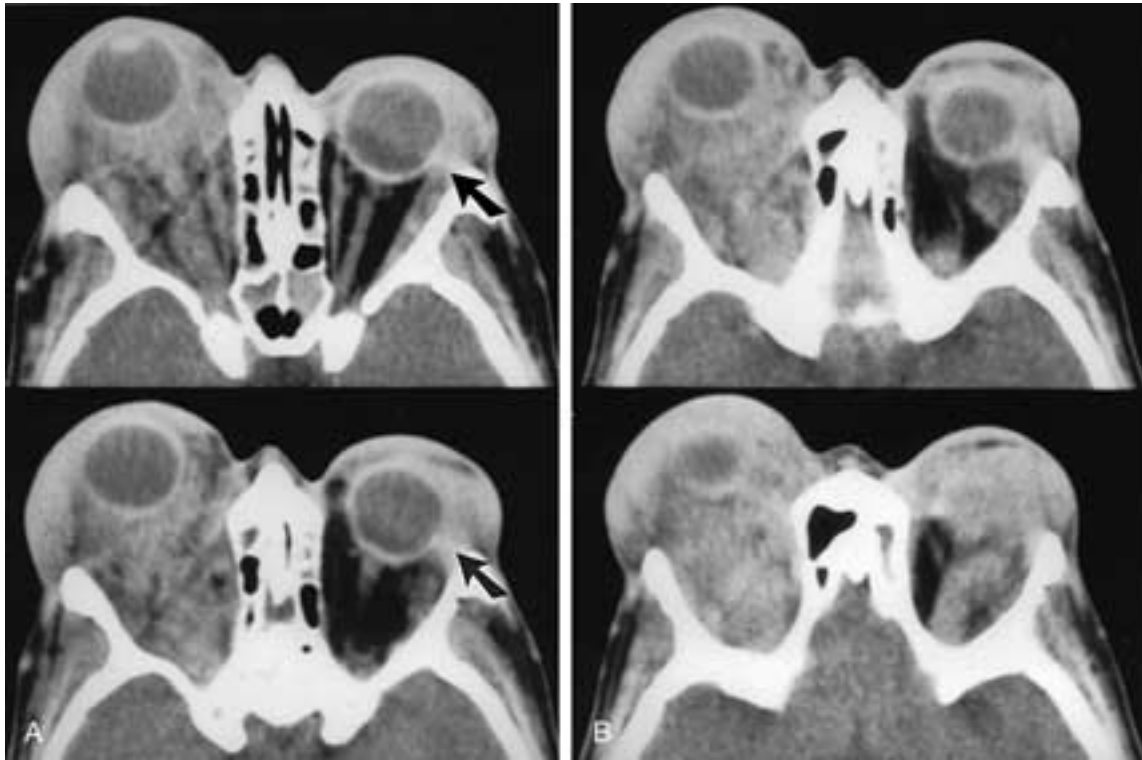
JXG of the orbit in an adult. A, Axial enhanced CT scans show proptosis and a diffuse infiltrative process involving the right orbit. There is abnormal soft-tissue thickening (*arrows*) of the left orbit as well. B, Enhanced axial CT scans show a marked infiltrative process involving the right orbit and, to a lesser extent, the left orbit. The differential CT diagnosis is bilateral pseudotumor, lymphoma, Wegener's granulomatosis, and necrobiotic xanthogranuloma. (From Hidayat AA et al. Langerhans' cell histiocytosis and juvenile granuloma of the orbit. *Radiol Clin North Am* 1998;36:1229–1240.)
